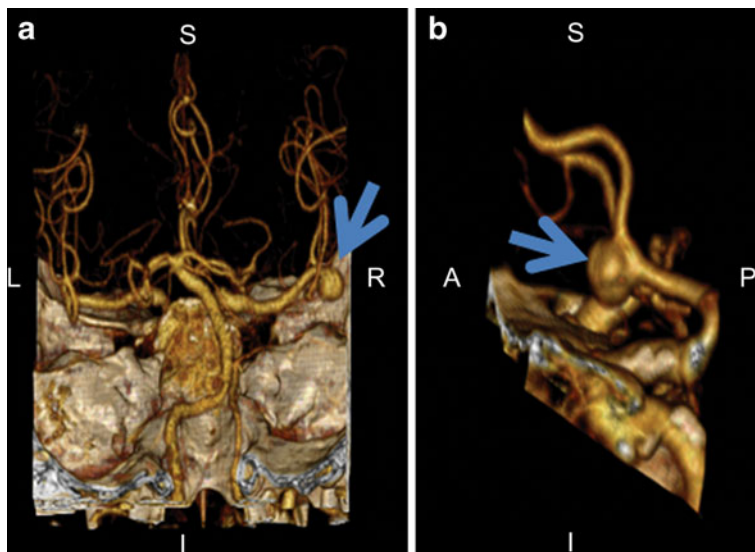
3-Dimensional CT angiographic images of intracranial aneurysms. (a) Right middle cerebral artery aneurysm (arrow), b anterior communicating artery aneurysm (arrow). A = Anterior, P = posterior, S = superior, I = inferior, L = left, R = right. (High resolution version of this image is available in the [electronic supplementary material](#).)
